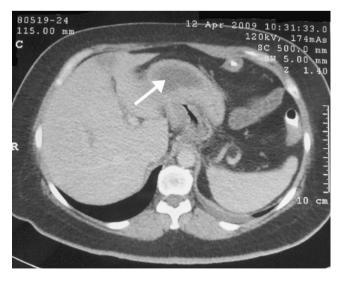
CT scan: *white arrow* indicating the seroma within the plicated gastric walls
